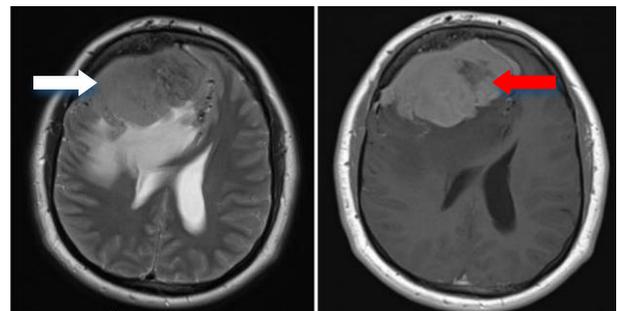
Preoperative, MRI brain of the lesion showing iso-intense signal (White arrow) in the T2-weighted sequence. The tumor homogeneously enhanced with areas of central hypointensity (Red arrow) in post-contrast, T1-weighted images.
